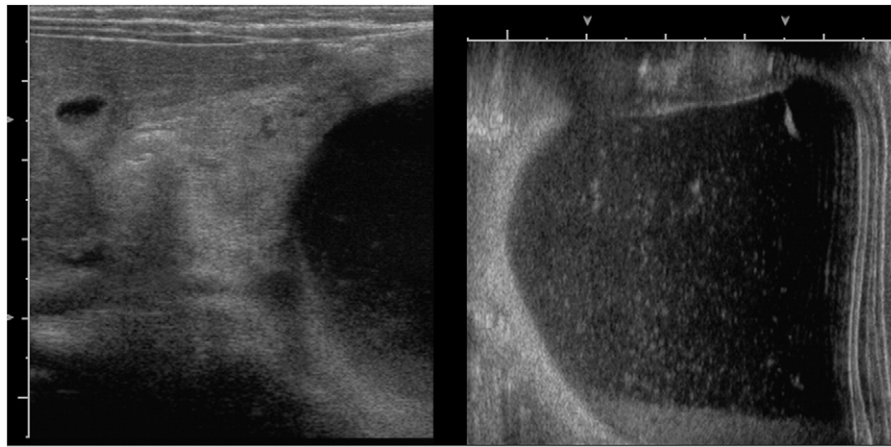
Abdominal ultrasound after referral of the patient. Cyst with sedimentation located just below the liver.
